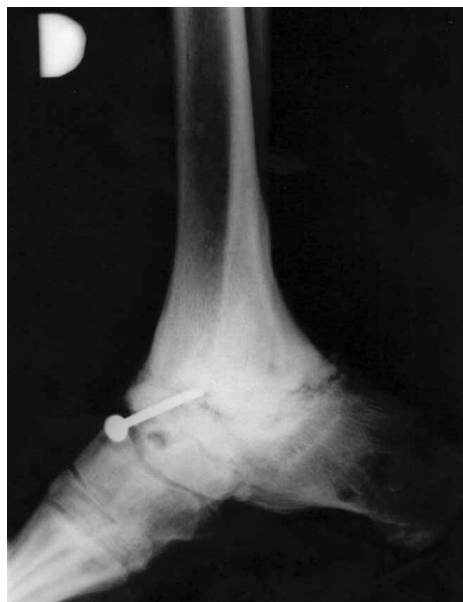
Lateral radiographs of the ankle 10 months after second operation showed bone consolidation in the arthrodesis region.
